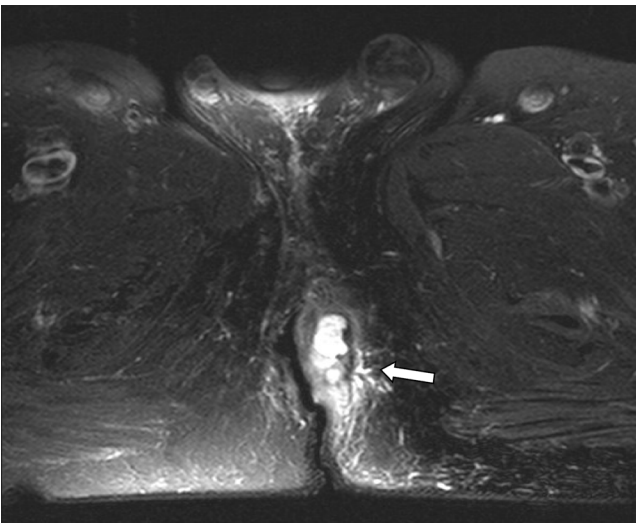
Fistula presenting in pelvic MRI.
